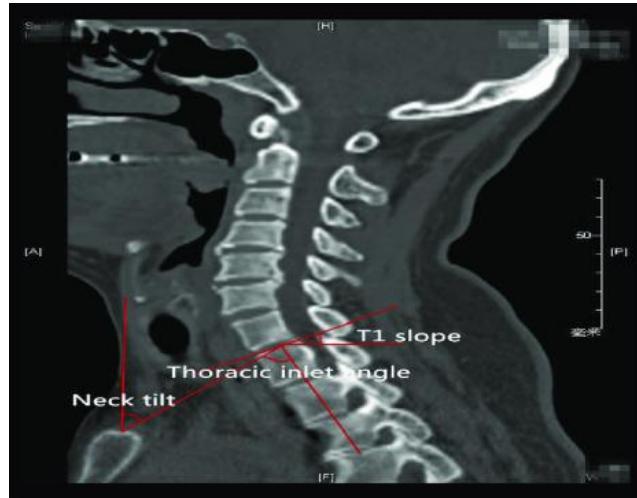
The Neck area tilt and slope (X-ray Image) [61]
